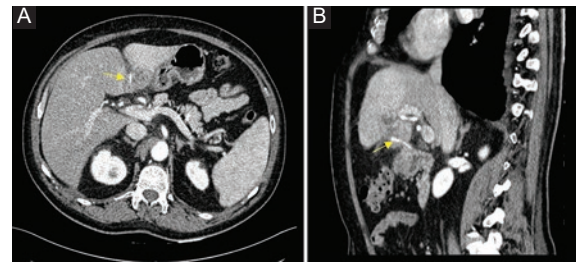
A-B: abdominopelvic CT, axial and sagittal section respectively. Marked with a yellow arrow an image of hyperdense foreign body.
